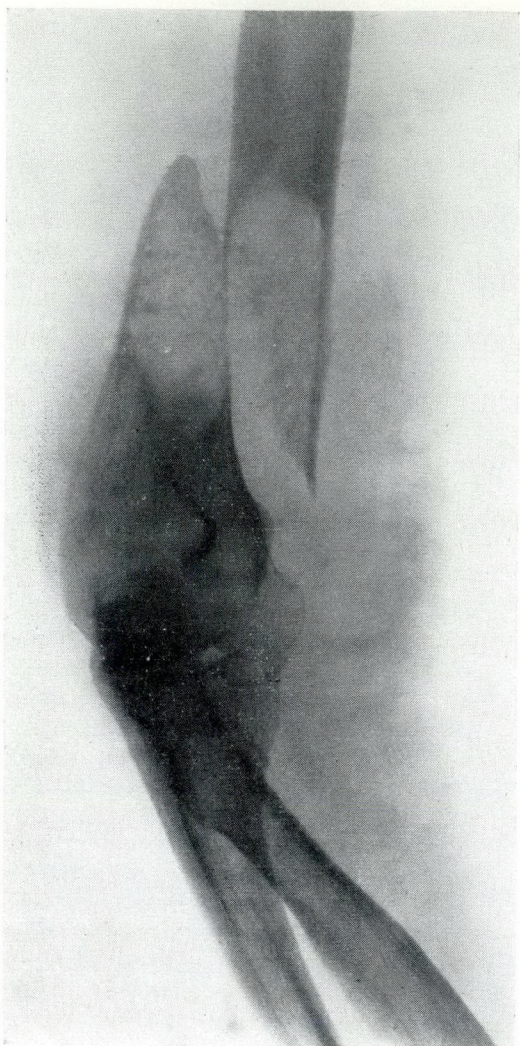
Radiograph of the lower end of the humerus showing the oblique fracture through the osteolytic lesion in the lower third of the humerus.
